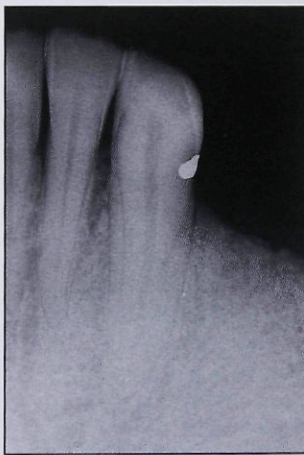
Seven-month postoperative radiograph showing fill of the bony defect.
